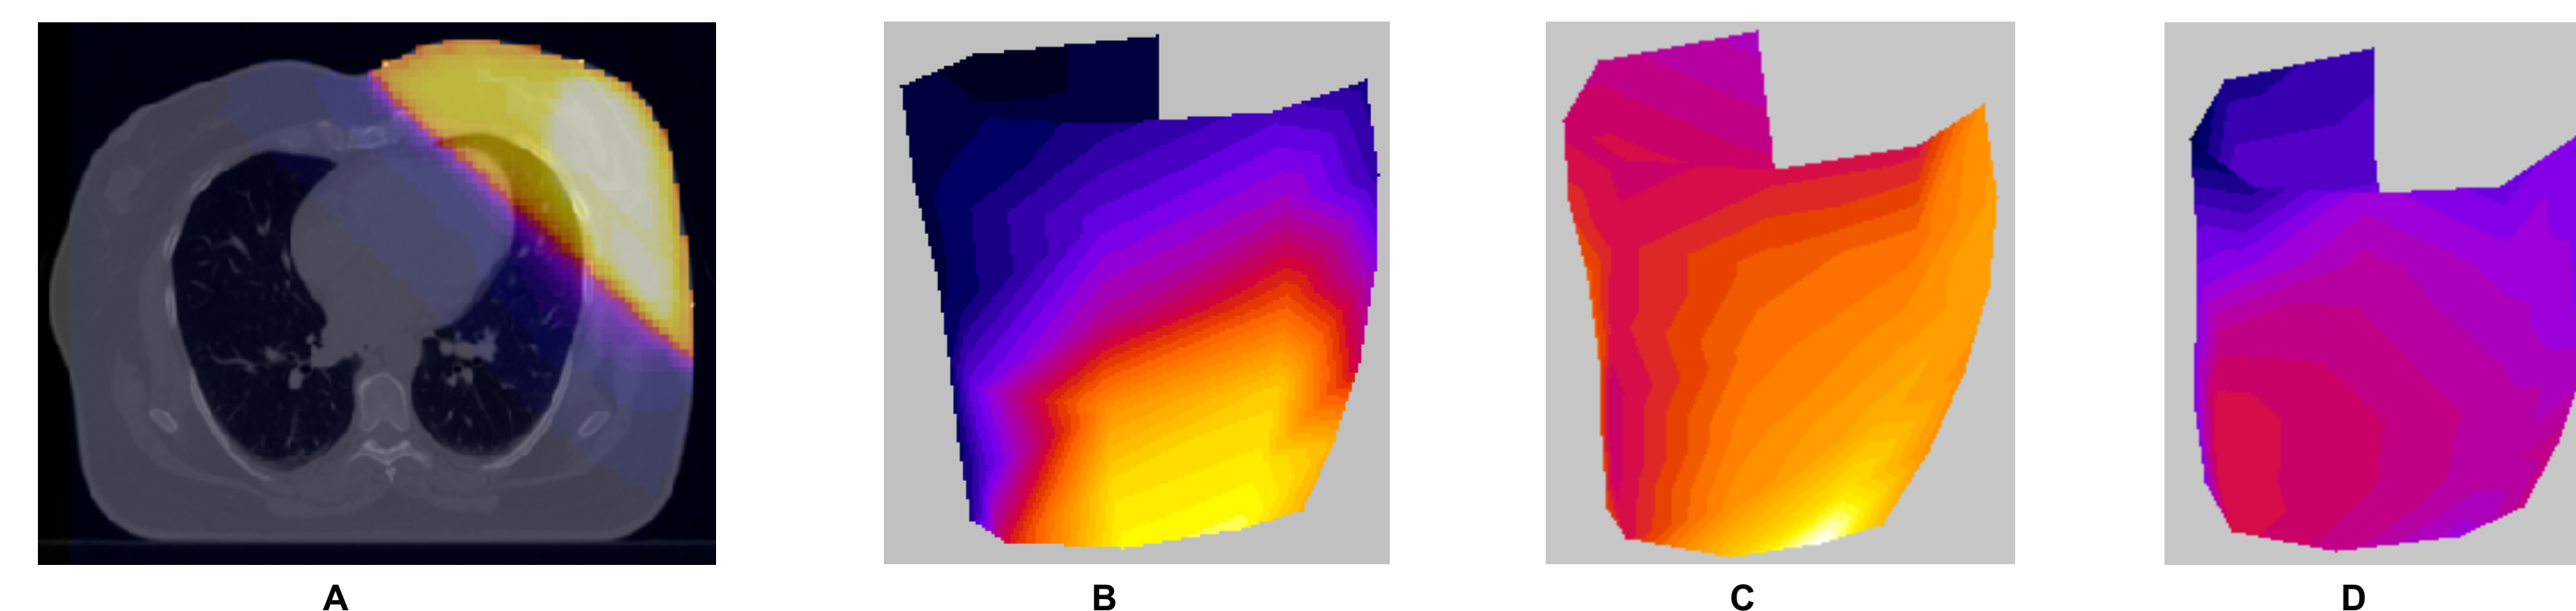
Heart dose calculation : [A] shows the radiation dose on a planning CT image showing elevated exposure to the anterolateral left ventricular wall and apex. [B] shows the dose distribution overlaid onto the 3D mesh of mid-wall material points. The yellow region indicates high radiation exposure while black indicates low exposure (range 2 to 47 Gy). [C] and [D] show mid-wall thickening strain at pre-RT and post-RT, respectively, with color scaled from 0 (black) to 1.0 (white). This is the color 3D rendering of the data of Figure 4B. Thickening strain is diminished over the entire heart, with larger apparent decrease in the regions with higher dose.
